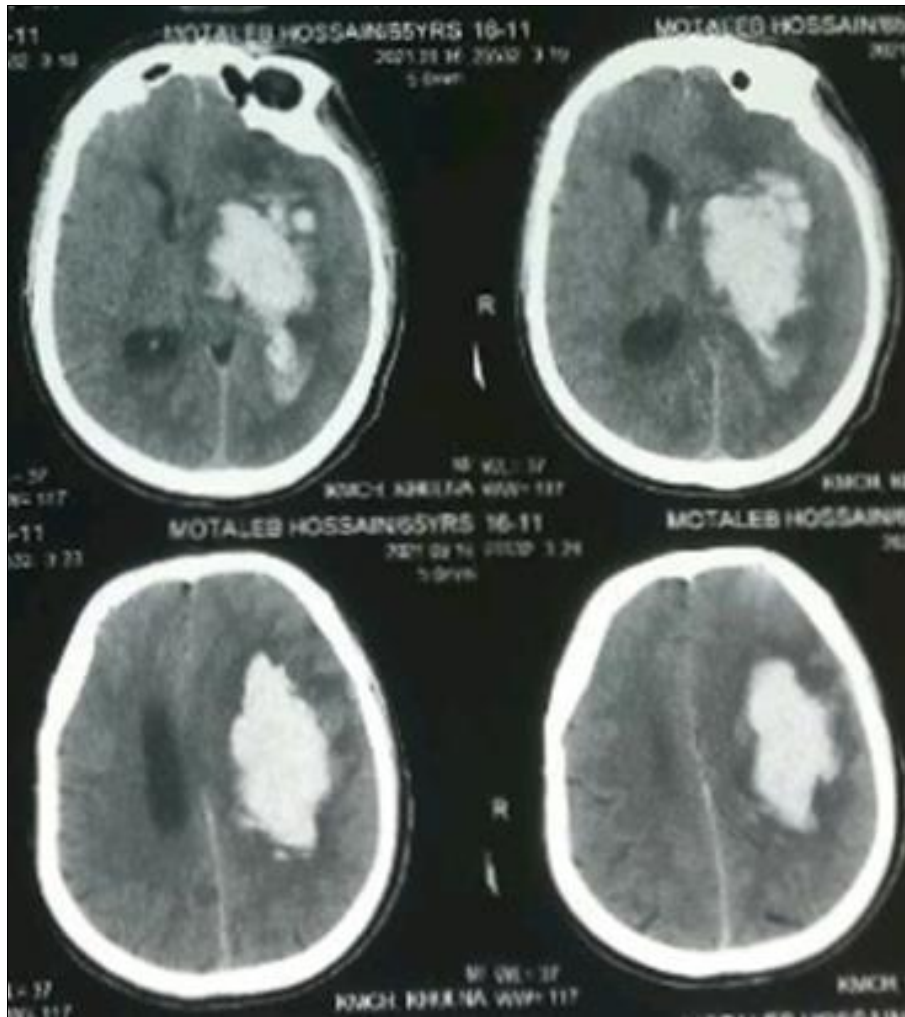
Spontaneous IPH on non-contrast CT scan head
